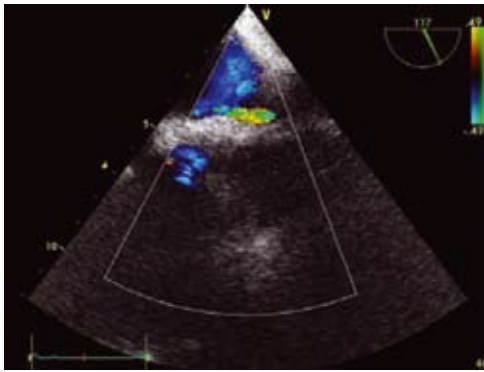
Significant turbulancy in color Doppler study of SVC flow
